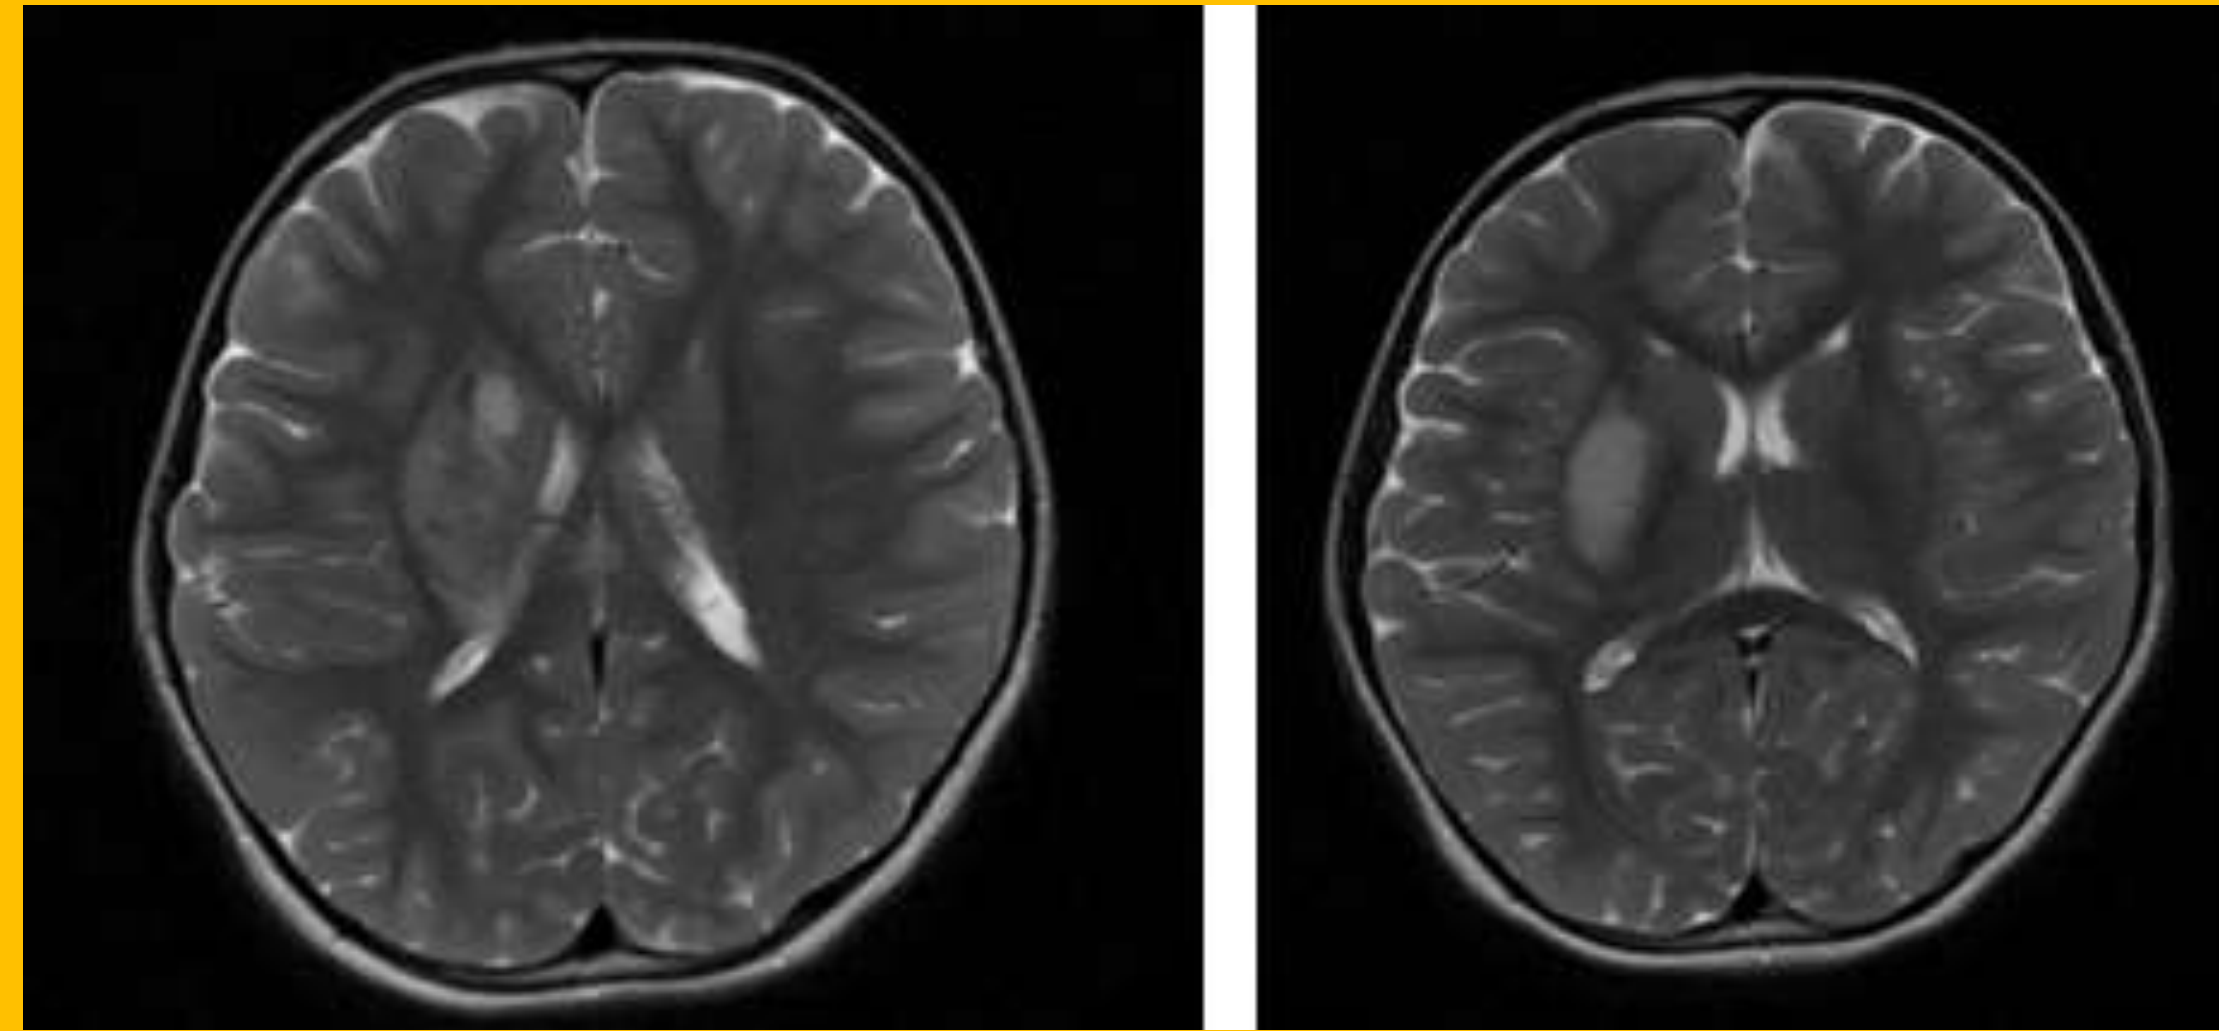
Axial T2-weighted magnetic resonance image of brain , showing hyperintense area ( acute infarct ) involving the right globus pallidus, putamen and part of posterior limb of internal capsule
